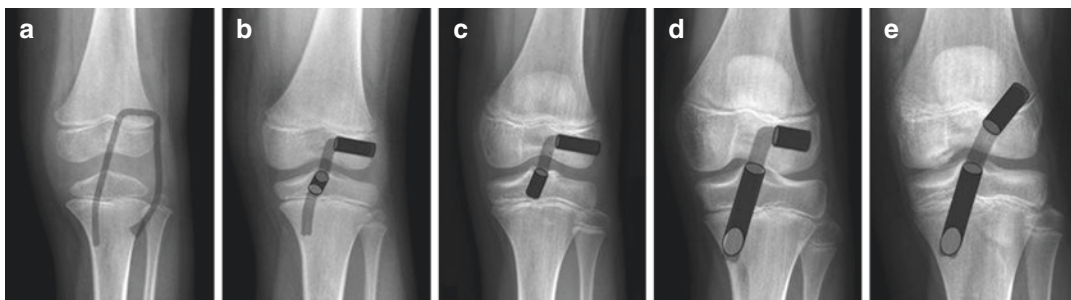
Radiographs revealing representative images of patients with bone ages of 6–14. (a) Bone age of 6: Micheli–Kocher intra-articular extra-articular procedure. (b) Bone age of 8: Anderson all-epiphyseal procedure, which has been modified. (c) Bone age of 10: Ganley–Lawrence all-epiphyseal docking procedure. (d) Bone age of 12: Hybrid all-epiphyseal femoral transphyseal tibial procedure. (e) Bone age of 14: Transphyseal femoral and tibial reconstruction with soft tissue only at the level of the physis. Reprinted with permission: Milewski et al. Clinics in Sports Med. 2011
